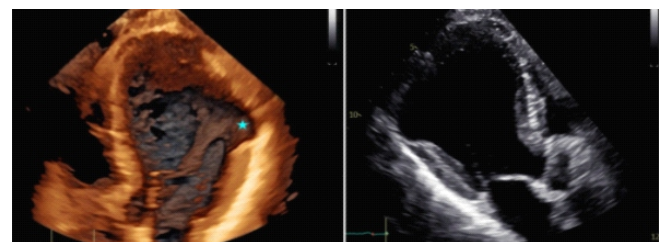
Dobutamine stress echocardiography showing a chronic left ventricular aneurysm with adverse remodeling. (Left) Rendered echocardiographic view demonstrating outward bulging of the aneurysmal left ventricular segment. (Right) Conventional grayscale echocardiographic view confirming the aneurysmal cavity with persistent akinesia of the involved segments.
